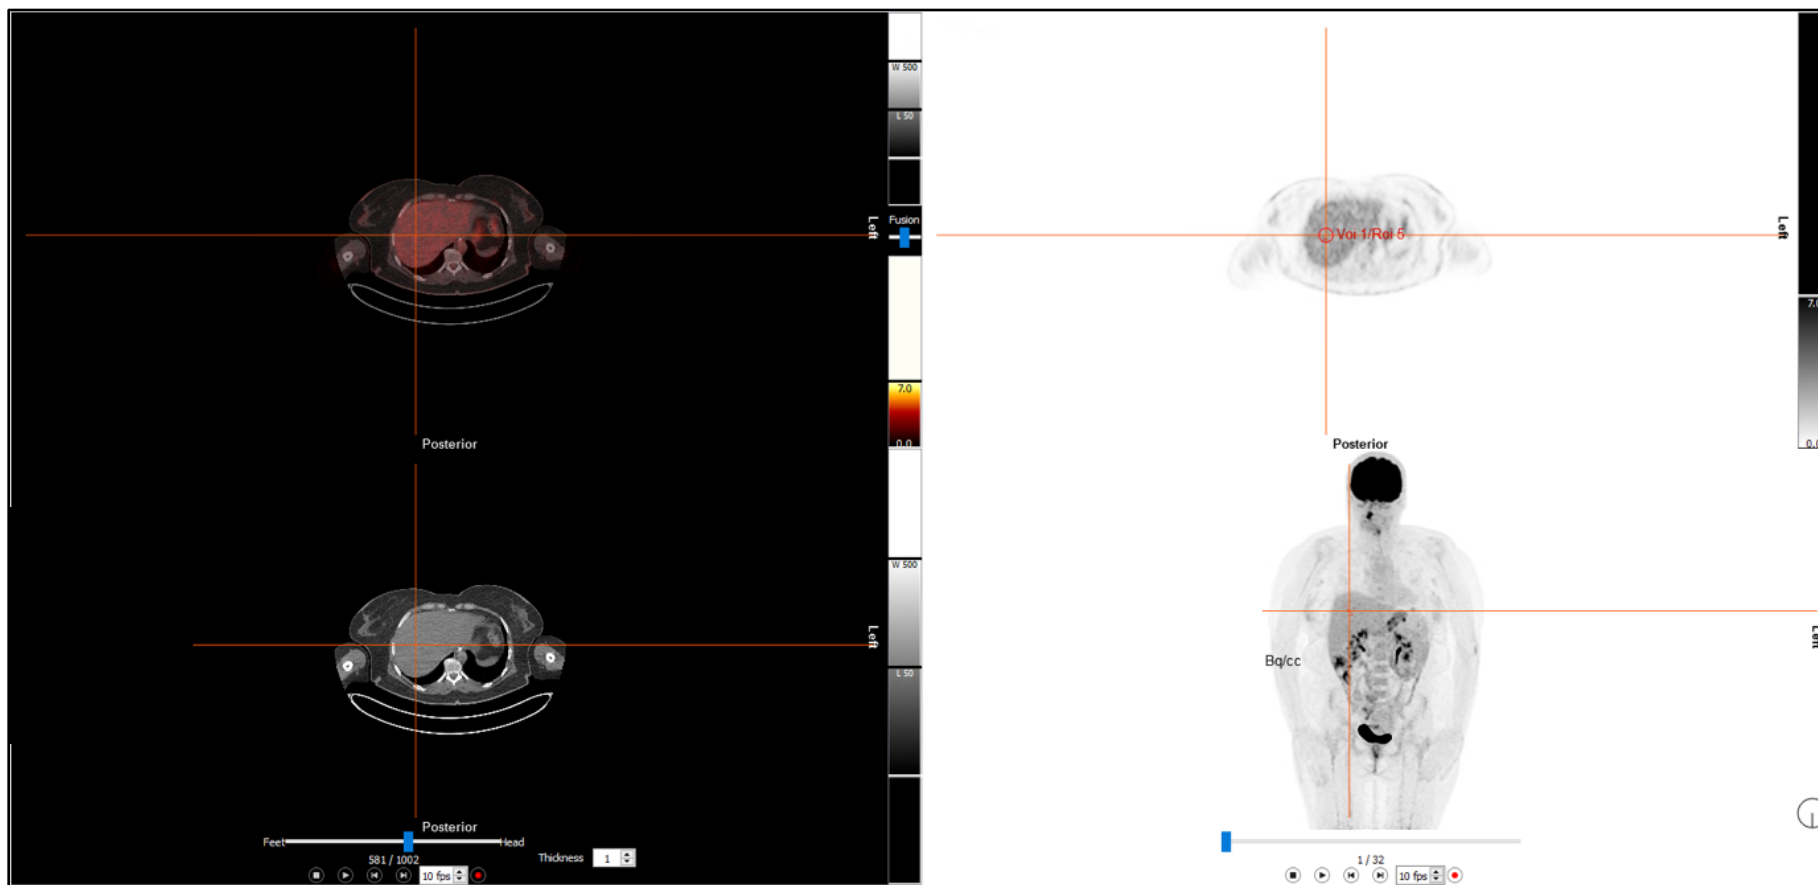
The liver  $SUV_{mean}$  and  $SUV_{max}$  derived from a fixed-size VOI drawn over the right lobe of the liver.
